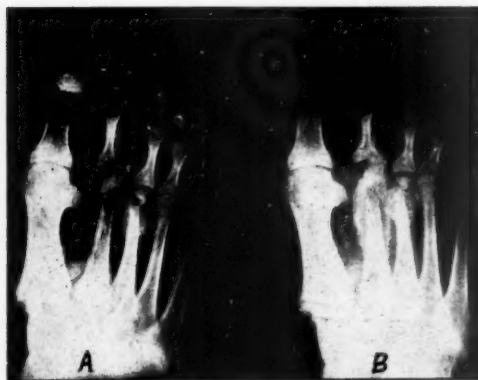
The more acute variety of osteitis. The bones were normal when the underlying ulcer first developed. Radiographs taken subsequently show: A, Two months later. Partial destruction of the 2nd and 3rd metatarsal heads and medullae with some periosteal new bone formation. B, Three months later. Repair of the affected shafts with marked periosteal new bone formation.
